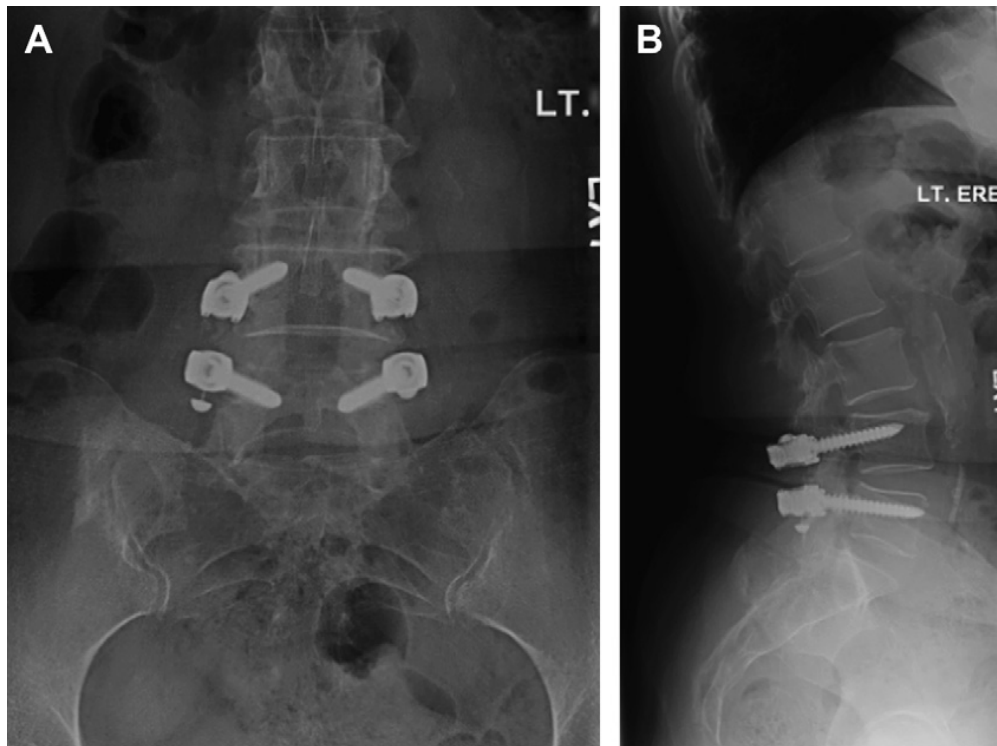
Anterior-posterior and lateral radiographs of lumbar spinal fusion (L4-L5) using pedicle screws with PEEK rods. PEEK is a radiolucent material, and as such the majority of the rod does not show up on the radiograph [25]. (Image reprinted with permission of Elsevier©)
